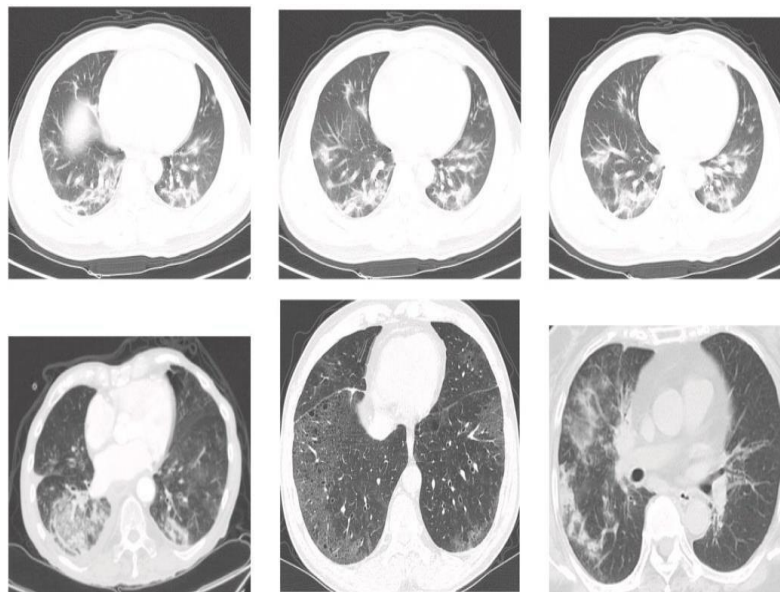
Examples of CT images
